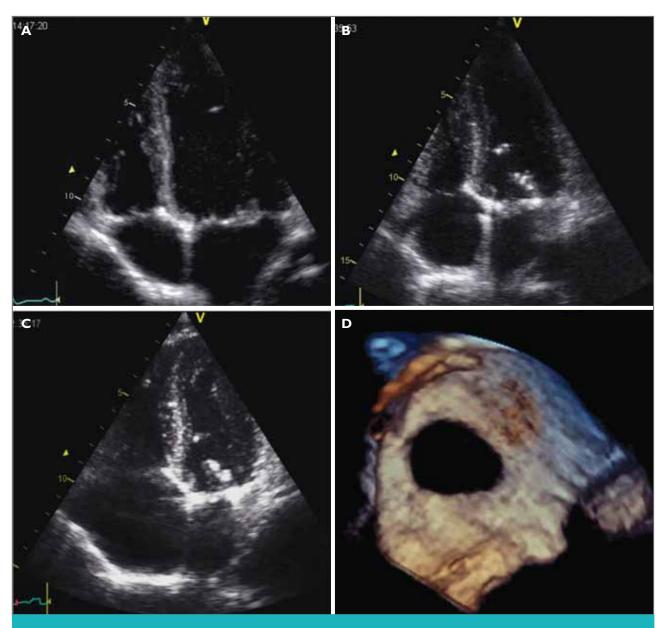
Pre-operative apical 4 chamber showing a dilated left ventricle and left atrium due to severe MR.
